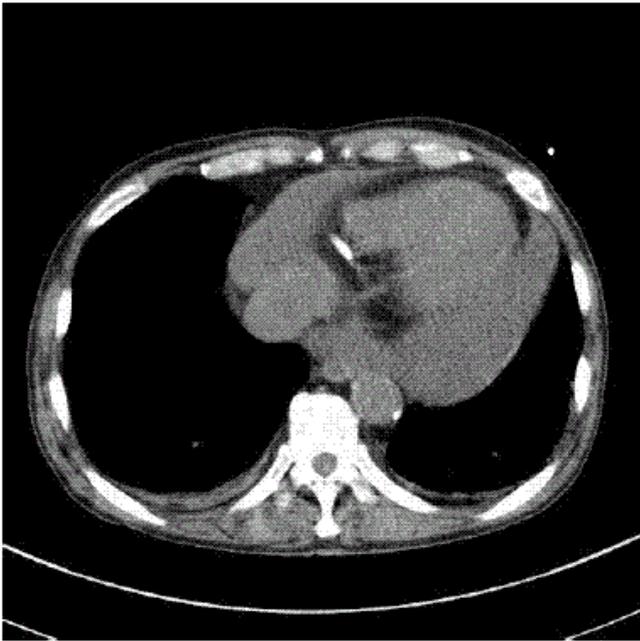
Chest CT for Case 1, showing massive pericardial effusion.
